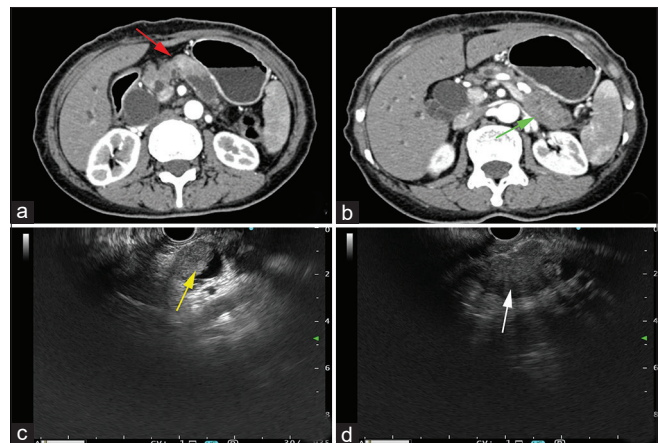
Contrast-enhanced computed tomography displaying multifocal nodules (a, red arrow) within the dilated pancreatic duct and a solid mass in pancreatic tail (b, green arrow). EUS showing slightly hyperechoic intraductal nodules (c, yellow arrow) in pancreatic body and a hypoechoic mass (d, white arrow) in the tail
